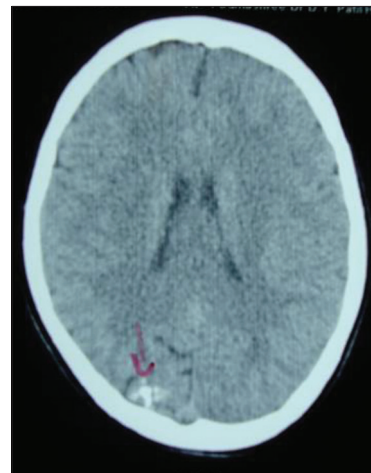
Computed tomography brain revealing abnormal, well-defined 0.5-cm-sized calcified lesions with perilesional gliosis
